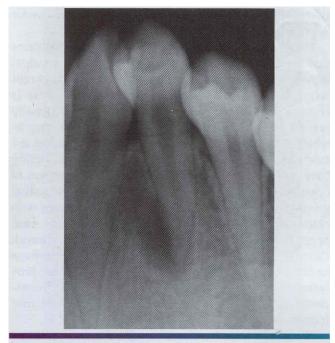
Dens evaginatus. Radiograph ofteeth depicted in Figure 2-65. Note the tuberculated occlusal anatomy. Attrition on the accessory cusp led to pulpal necrosis and periapical inflammatory disease.
